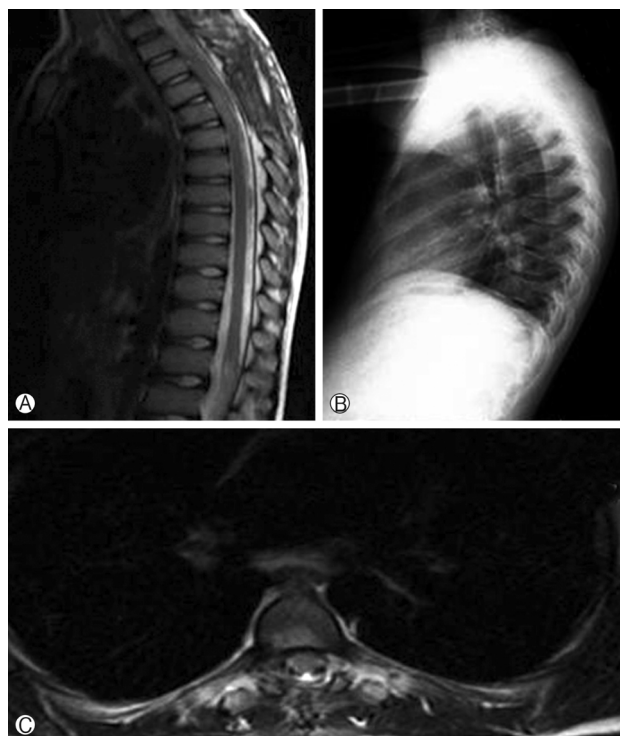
T2 sagittal, axial T2, T1 sagittal images show that the mass is totally removed and no mass effect is seen on medulla. Post operative changings can be seen in Posterior spine tissue. On X-ray images no significant finding is observed.
